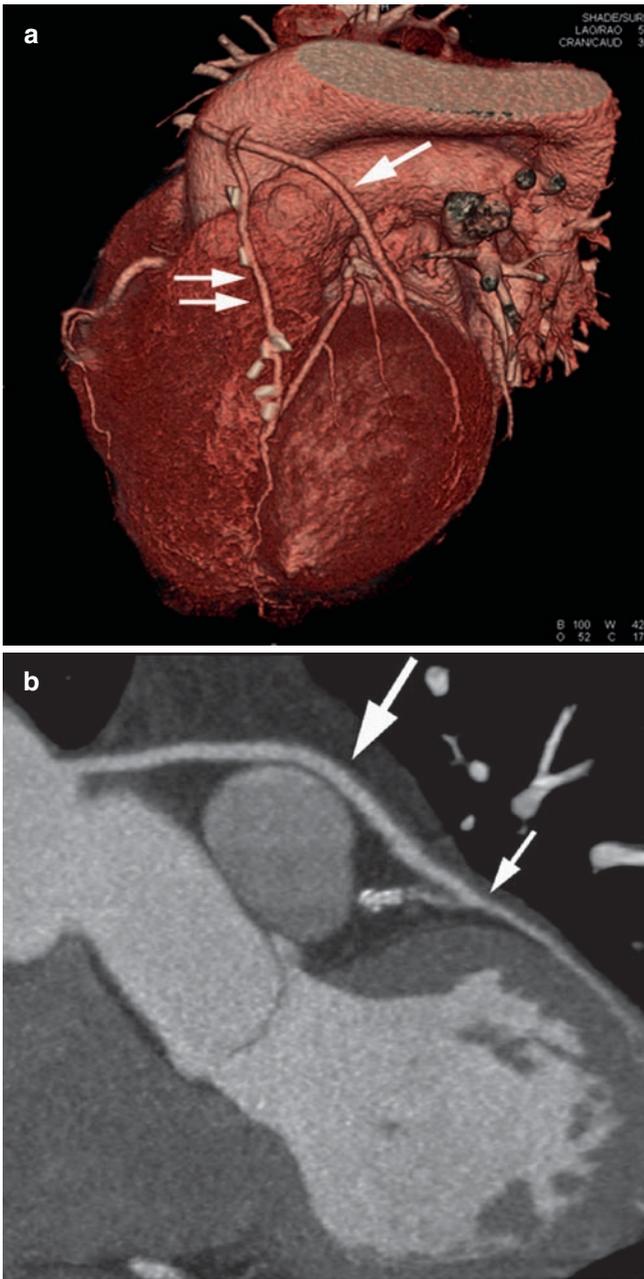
CT visualization of bypass grafts. (a) 3D reconstruction in a patient with an internal mammary artery graft to the left anterior descending coronary artery (*double arrows*) and a vein graft from the aorta to a diagonal branch (*large arrow*). (b) Curved multi-planar reconstruction of the bypass graft to the diagonal branch which shows the body of the bypass graft (*large arrow*), the coronary anastomosis (*small arrow*), and the distal lumen of the diagonal branch
